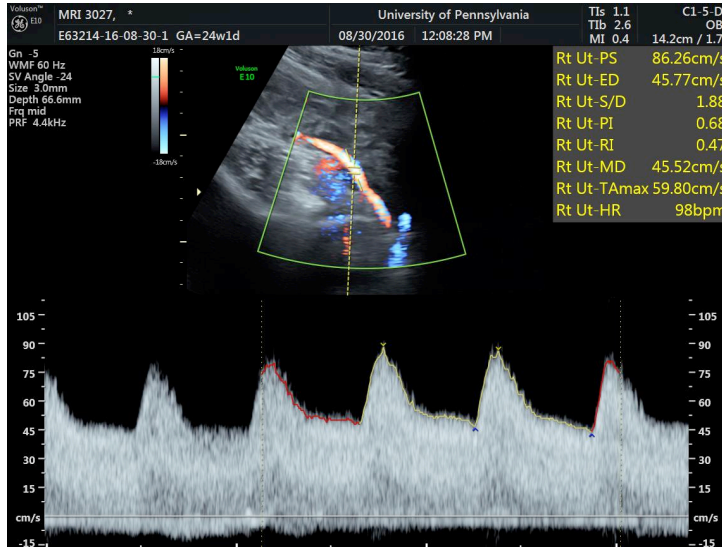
Example Doppler US of the right uterine artery in a representative subject
